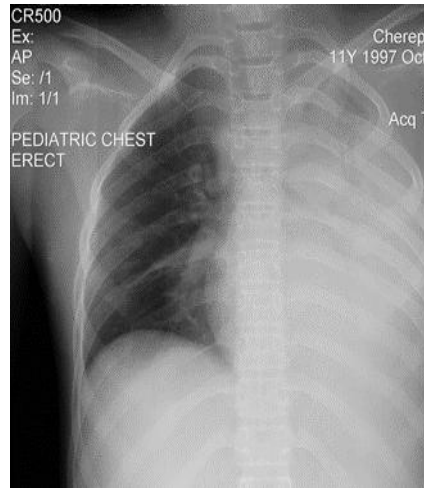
Chest X-ray showing pleural effusion in patient with mediastinitis due to esophageal injury
